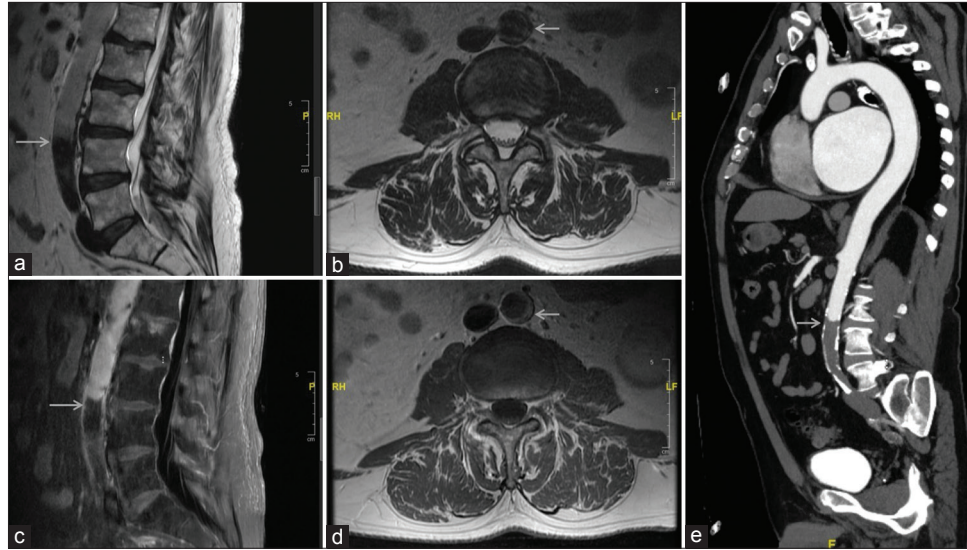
Magnetic resonance imaging of the lumbar spine. (a) T2-weighted image, sagittal. (b) T2-weighted image, axial. (c) T1 postcontrast, sagittal. (d) T1 postcontrast, axial. (e) computed tomography angiography of the chest, sagittal. The arrows depict the abrupt lack of contrast in the aorta, confirming acute aortic occlusion.
